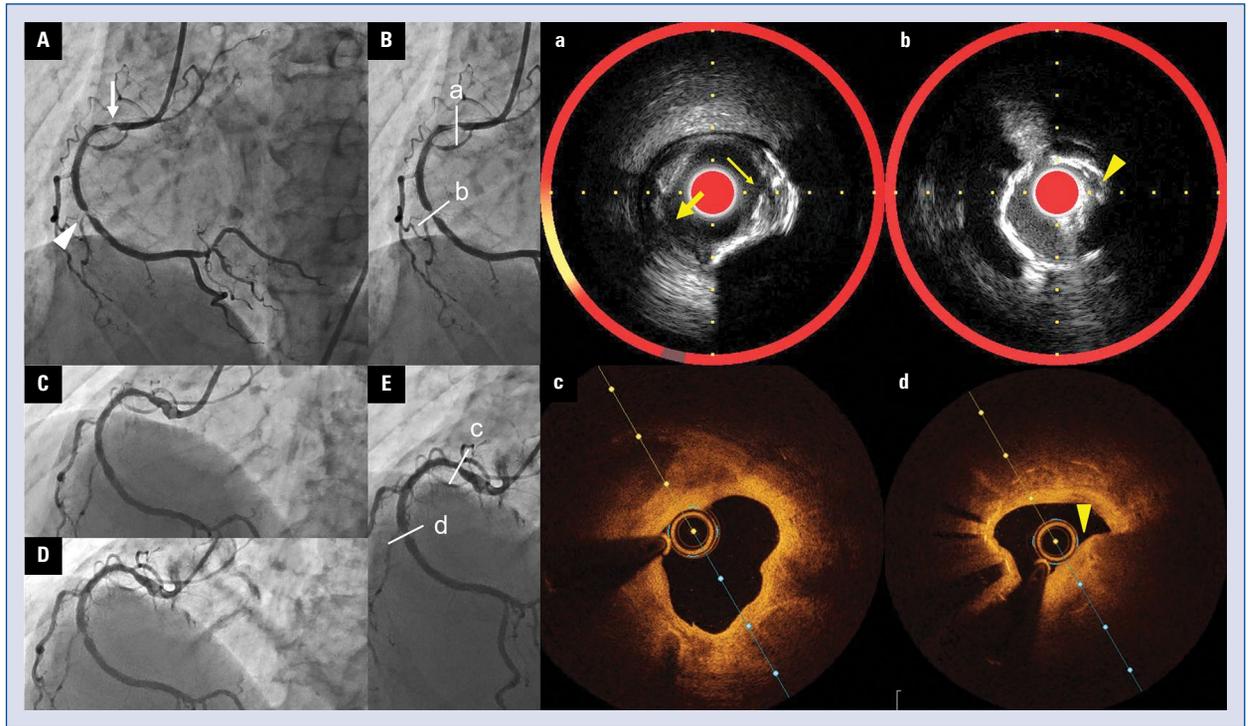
A. The initial coronary angiogram (CAG); B. Near-infrared spectroscopy-intravascular ultrasound; C. Final CAG; D. CAG at 6 month-follow-up; E. Optical coherence tomography.
